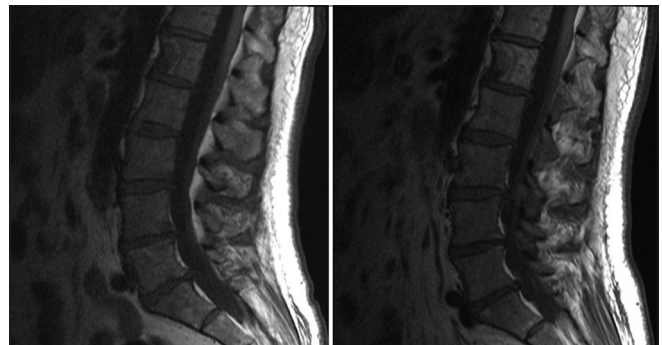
T2-weighted sagittal MRI images of L1 vertebra before XRT (left) and after XRT (right)
